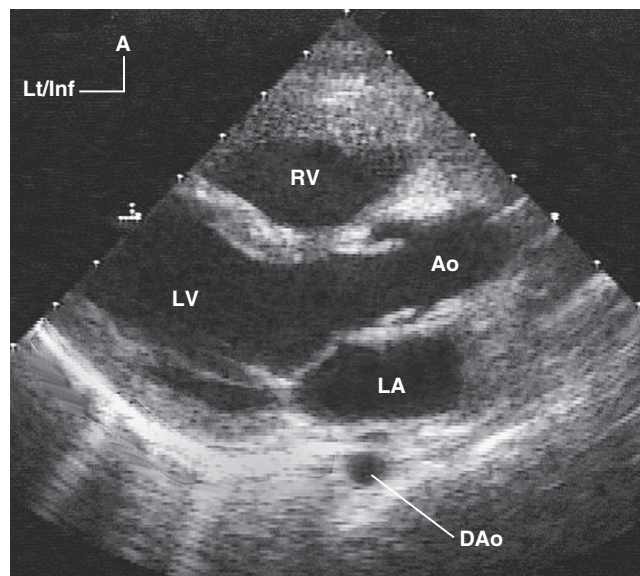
■ Two-dimensional image from the parasternal long-axis view showing the left atrium (LA), left ventricle (LV), aortic root (Ao), descending aorta (DAo), and right ventricle (RV).
